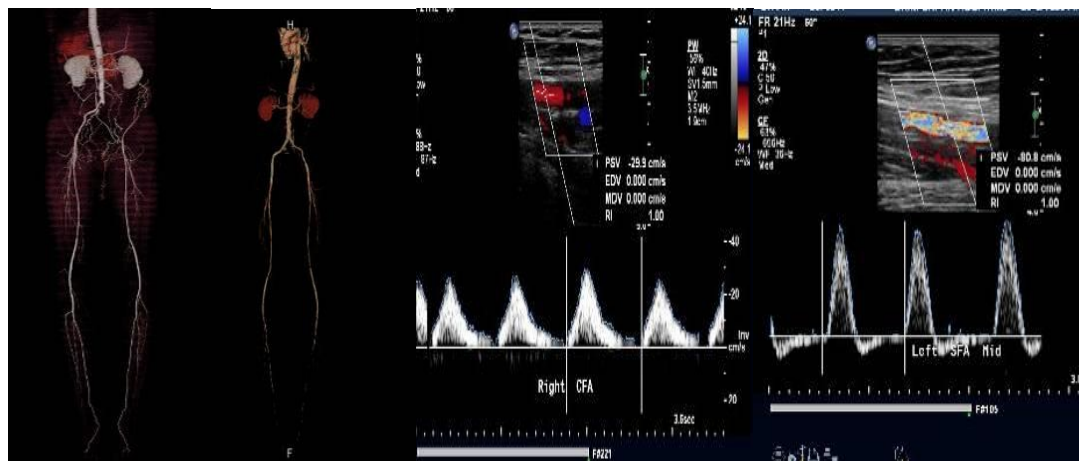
Showed CT angio & duplex of pre & post iliac occlusion & angioplasty with stenting
